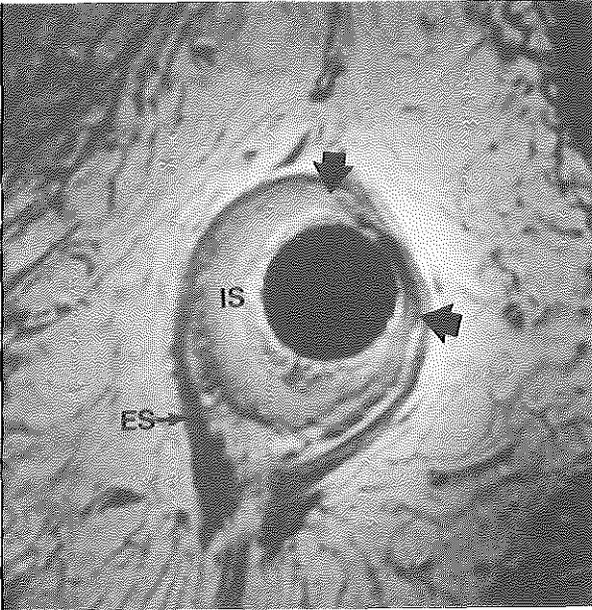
Endoanal MRI, axial proton density weighted GRE showing an internal sphincter (IS) defect (arrows). External sphincter (ES). The patient presented with fecal incontinence after hemorrhoidectomy.
